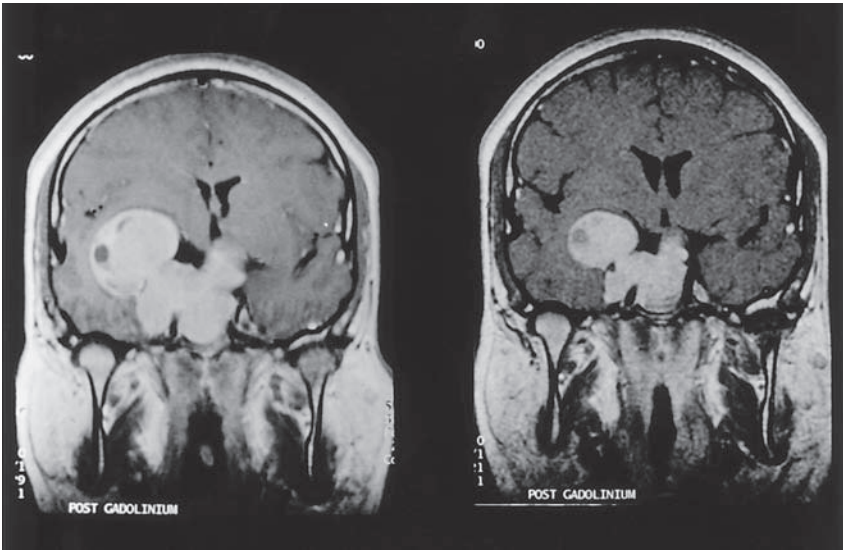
This 26-yr-old-man presented via the ophthalmology clinic with a 6-mo history of headache and decreased color vision and a 1-mo history of bitemporal visual field loss. He also described episodes suggestive of temporal lobe epilepsy. Initial serum prolactin level was enormously raised at 821,000 mU/L (normal <300) and MRI showed a 7.4-cm invasive macroadenoma, extending into the right temporal lobe (left hand panel). Serum testosterone was reduced at 4 nmol/L and gonadotropin concentrations were low. Thyroid and adrenal functions were normal. He commenced cabergoline 0.5 mg twice weekly, and the dose was incremented to 1 mg twice weekly after 4 mo. His headaches subsided within 1 mo, visual fields were normal after 4 mo and the TLE episodes disappeared. Serum prolactin fell to 84,060 mU/L after 4 d and to 12,790 mU/L after 9 mo. MRI showed a considerable reduction in tumor size after 3 mo of medical therapy (right hand panel).
